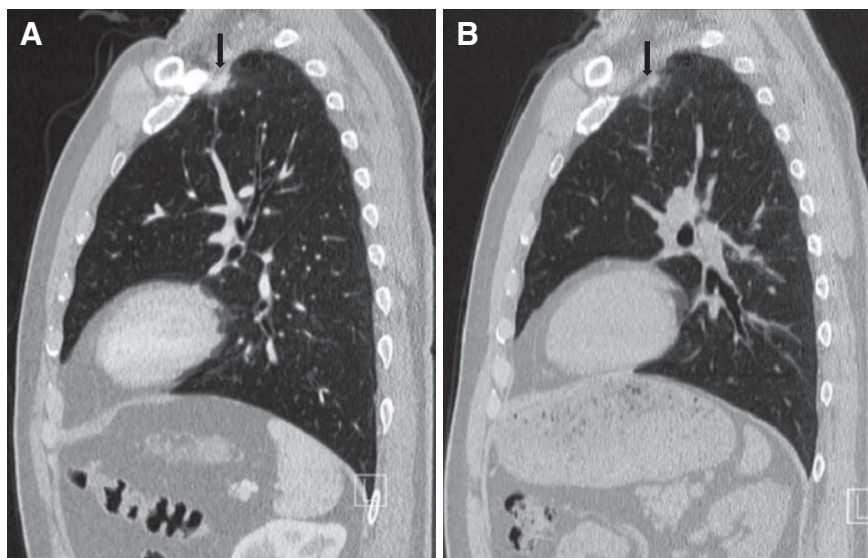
Computed Tomography images of the initial presentation (A) and 2 months post-Erlotinib treatment (B) of the lung nodule.
